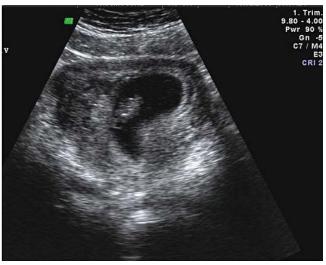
4th Presentation 8 weeks 4 days. Ultrasound findings: The 2nd gestational sac was poorly visualised. The sac borders were ill defined and it appeared to be filled with material of mixed echogenecity (arrow). b-hCG not recorded.
